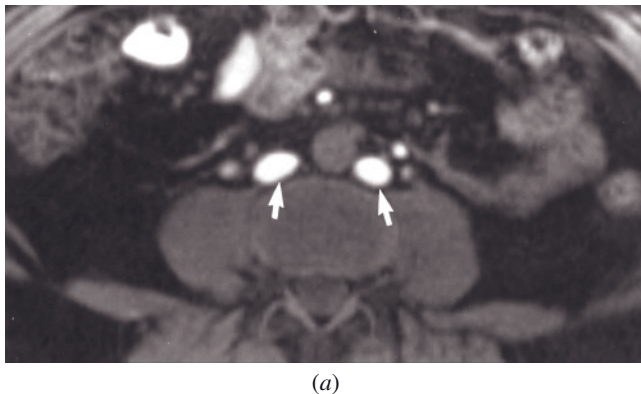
Duplicated IVC. Noncontrast fat-suppressed SGE (*a*), immediate postgadolinium (*b*), and interstitial-phase gadolinium-enhanced SGE (*c*) images in a patient with duplicated IVC. The noncontrast T1-weighted image shows high-signal time-of-flight effects in venous structures on the inferior sections of the data acquisition. The bilateral IVCs (arrows, *a*) are clearly appreciated with the time-of-flight effects. The capillary-phase image (*b*) shows lack of enhancement of the IVCs early after contrast, which then become opacified on the interstitial-phase image (*c*). Combining morphologic and directional flow information on the precontrast images with dynamic temporal flow information on serial postgadolinium SGE images permits evaluation of congenital vascular variations and malformations.
